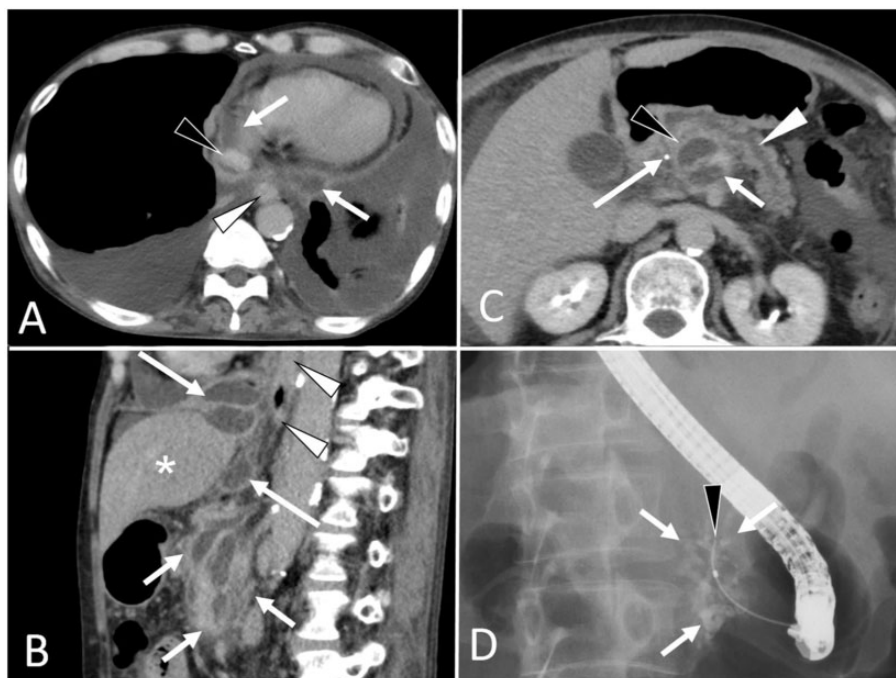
Pancreatic pseudocysts in Case 3. (A) Axial enhanced chest CT at symptom onset. Mediastinal fluid collections with cystic lesions (arrows) extend along the esophagus (arrowheads in white) and inferior vena cava (arrowhead in black). Bilateral pleural effusions and pericardial effusions are seen. (B) Sagittal enhanced lower chest and upper abdominal CT at symptom onset. The connection between the cysts (arrows) around the liver (asterisk) and the esophagus (arrowheads in white) and the pancreas head with multiple cysts (short arrows) is well identified on the sagittal image. (C) Axial enhanced upper abdominal CT at symptom onset. The pancreas head with multiple cysts (short arrow) and calcification (long arrow) is seen. MPD dilatation (arrowhead in white) is seen in the pancreas body and tail. MPD stricture (arrowhead in black) is suspected in the pancreas head. (D) ERCP obtained 1 week after symptom onset. Dilatation and irregularity of the side branches (short arrows in white) and an MPD stricture (arrowhead in black) are seen in the pancreatic head region.
